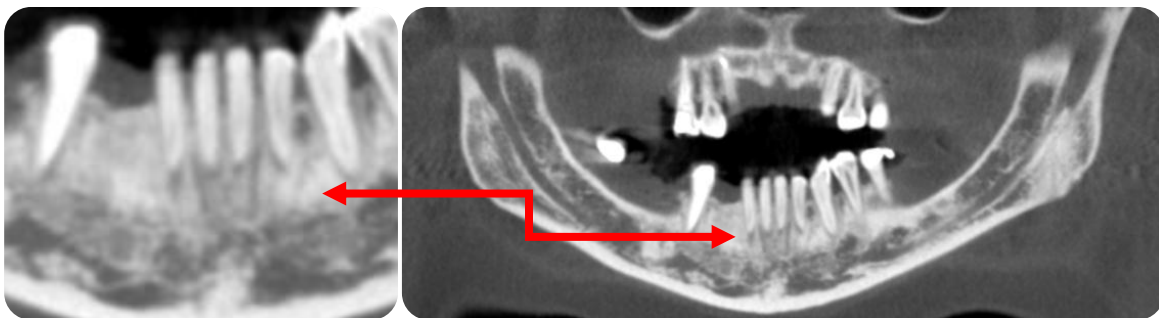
The Arch Section option (cropped); the panoramic section and the magnification of the lower anterior segment to reveal the Nutrient Canals (Red arrow), running vertically between the lower incisor teeth (Images obtained with i-CAT® Model 17-19; CBCT Imaging Unit: InVivoDental5 Version 5.2 Anatomage, software): Dentomaxillofacial Radiology Department; Faculty of Dentistry- University of Yeditepe.
